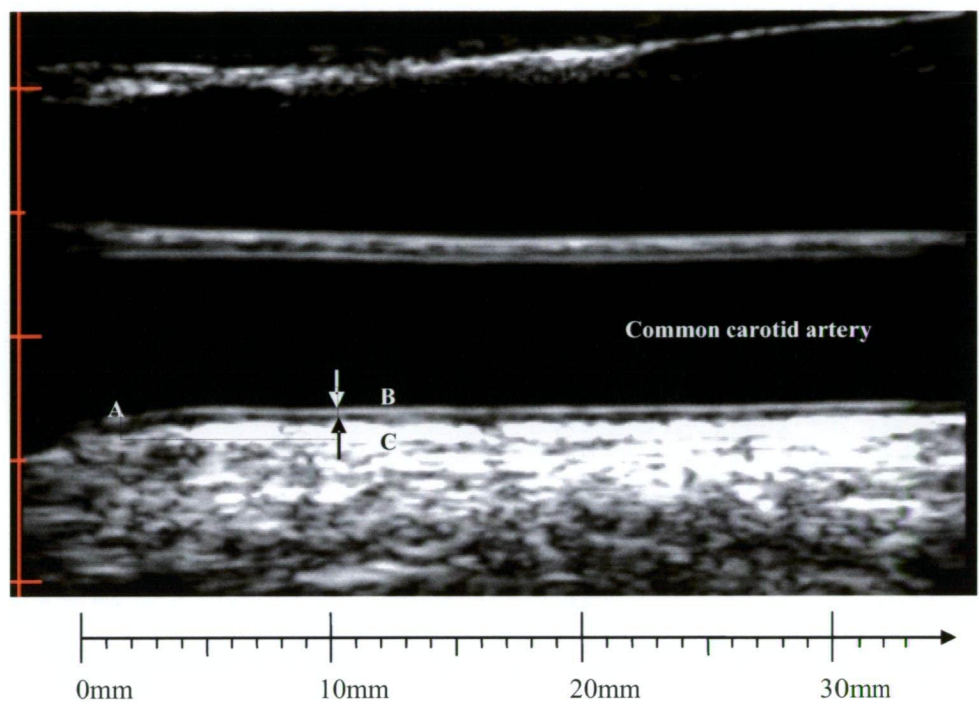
B-mode ultrasound image of the left common carotid artery (CCA): A) border of carotid bulb widening (0 mm), B) CCA far wall lumen-intima interface, C) media-adventitia interface. Definitions of the CCA segment in each cohort: CDAH and Young Finns, CCA IMT is taken as the distance between B and C measured in the vicinity 10 mm proximal to the border of the bulb widening (A); Bogalusa, CCA IMT is taken as the distance between B and C measured 0-10 mm proximal to the border of the bulb widening (measurement area highlighted by yellow box).
